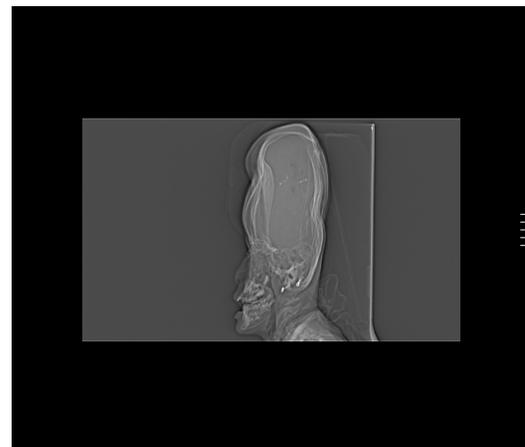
A CT scan of the head using volume rendering technique. This lateral view which shows the ventriculoperitoneal shunt in place. As well, The skull is flattened from the posterior edge. There is some motion artifact.
